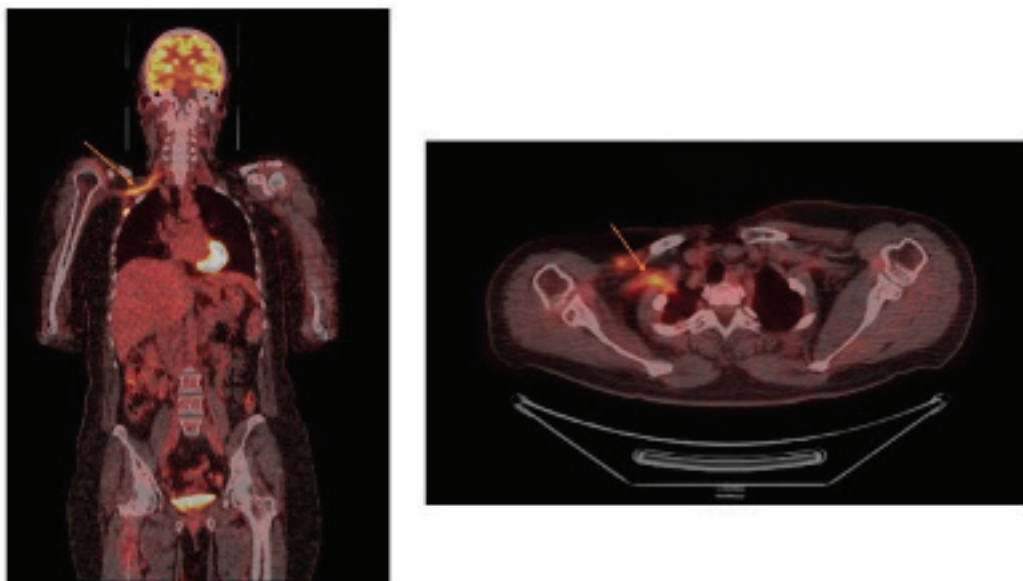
The coronal and transaxial fused PET/CT images revealed a linear pattern of FDG uptake in right brachial plexus (orange arrows). Brachial plexopathy is a rare condition with an incidence of less than 0.5%. Metastatic breast and lung cancers are the most common nontraumatic causes of brachial plexopathy following radiation induced plexopathy (1). MRI is the modality of choice for diagnosis of brachial plexopathy and preferred to other imaging modalities for characterization of brachial plexopathy due to its multiplanar capabilities and superior soft-tissue contrast. In MRI, radiation fibrosis shows diffuse thickening and minimal enhancement along the brachial plexus and MRI cannot always readily differentiate radiation-induced plexopathy from metastatic plexopathy (2). ¹⁸F-FDG PET/CT is a useful tool in the evaluation of patients with suspected metastatic plexopathy, particularly when MRI findings are suspicious (3). The typical pattern as seen in MIP and coronal images is linear uptake, extending from the superomedial aspect (supra/infra clavicular) to the lateral aspect of axilla closely related to the subclavian/axillary vessels (4). ¹⁸F-FDG PET/CT plays an important role in diagnosing neoplastic plexopathy, differentiating it from radiation-induced plexopathy and monitoring response to treatment.
